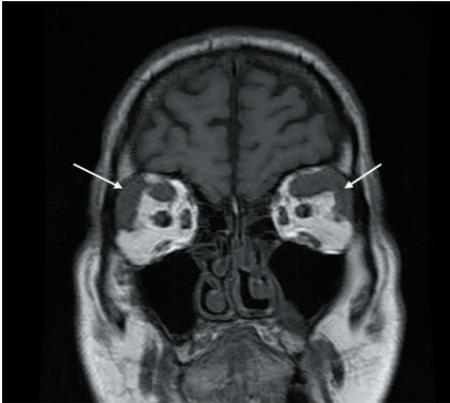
Axial T2 weighted MRI image showing enlargement of left and right lateral rectus muscles (arrows)
